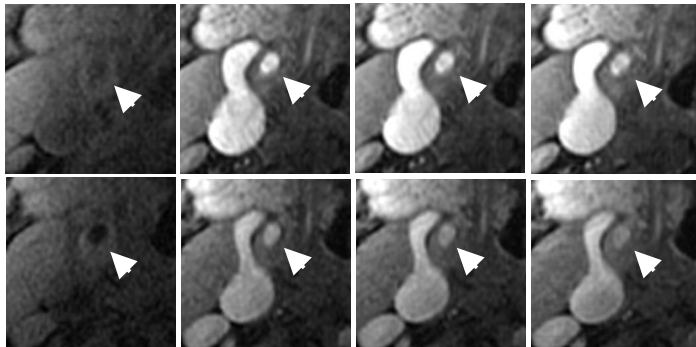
Qualitative reproducibility: dynamic CE-MRI of same artery (arrow) on two different days showing the first 4 time points in the sequence.
